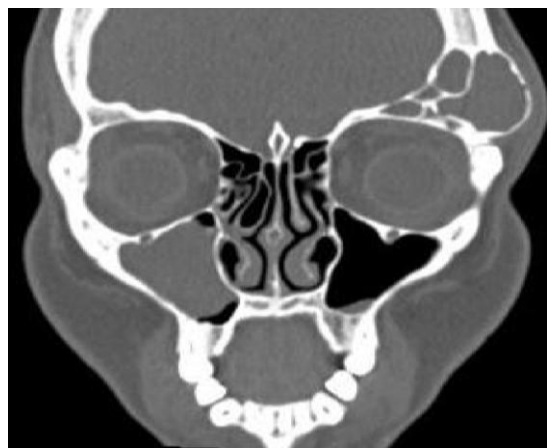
Coronal CT image showing right concha bullosa
